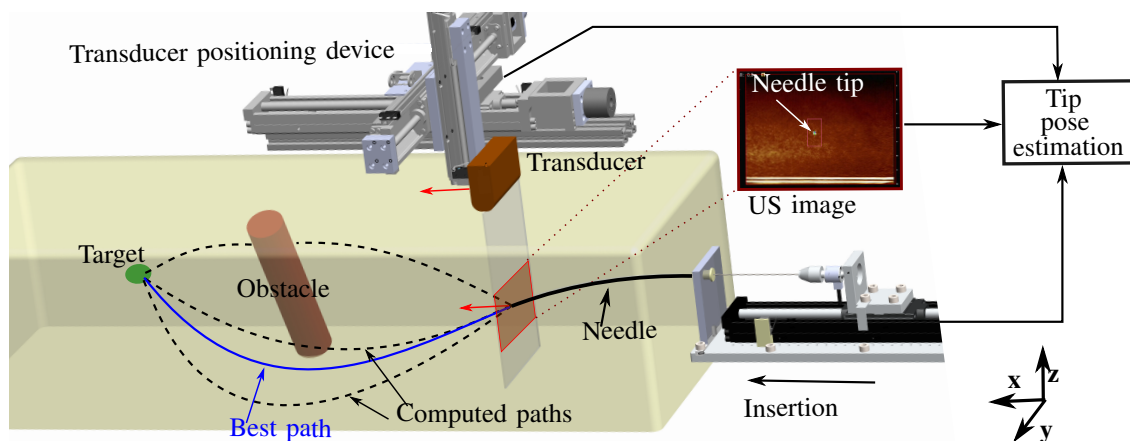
Needle tracking and path planning: The ultrasound (US) transducer is robotically positioned on the same plane as the needle tip. The tip pose is estimated using the information from the US image, the needle insertion device, and the transducer positioning device. The needle pose is used by the motion planner at each re-planning step to generate many feasible paths to the target. The planner selects the best path such that the needle path length is minimized while avoiding obstacles.
